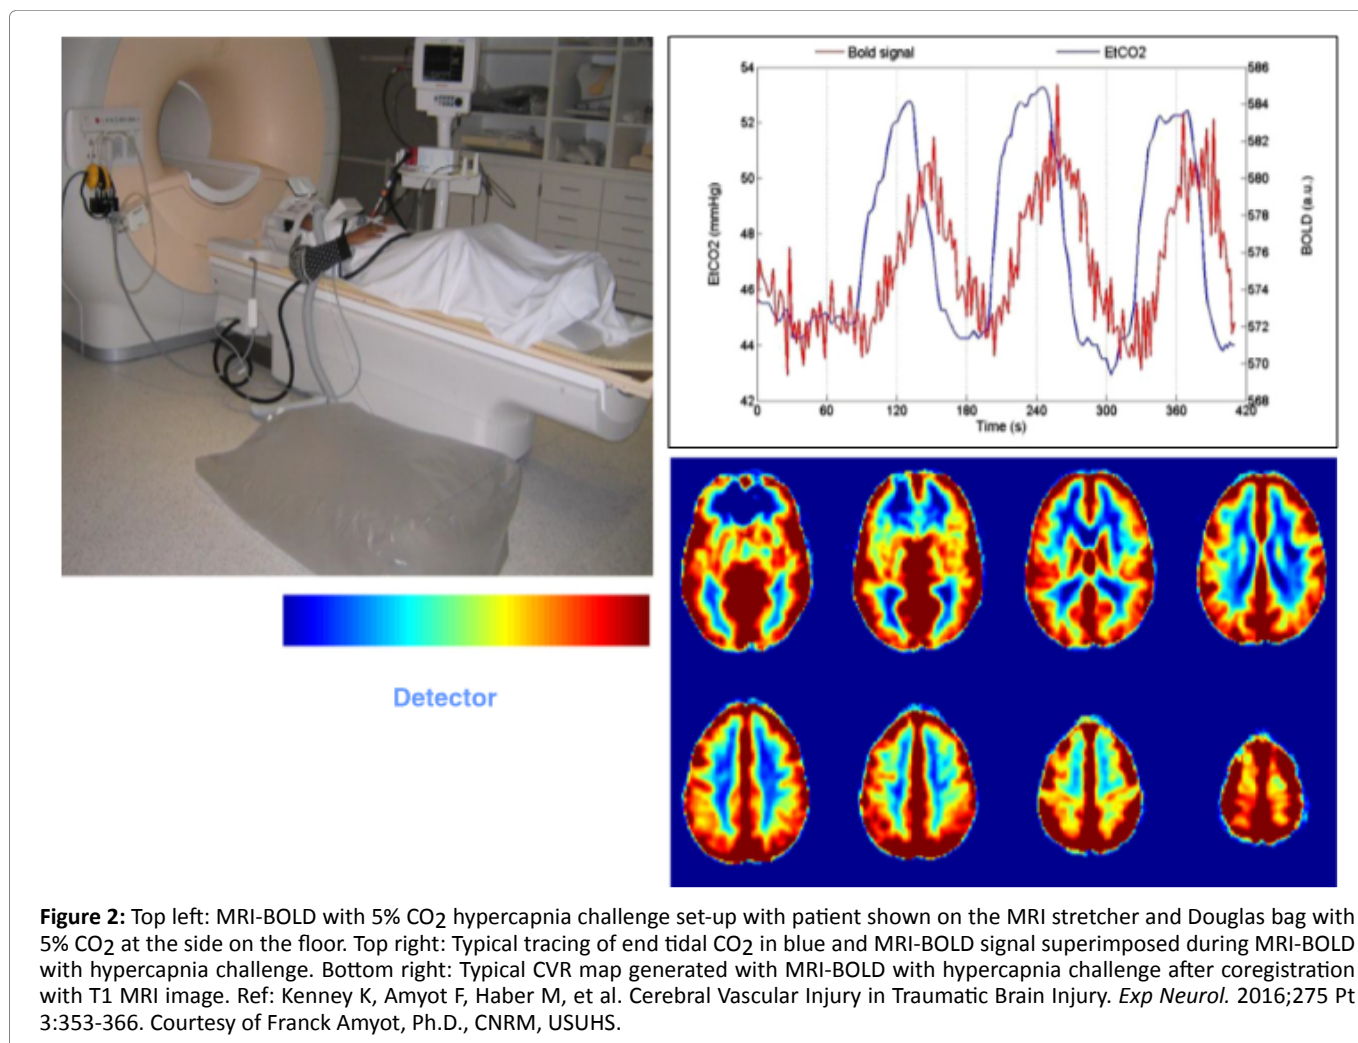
Top left: MRI-BOLD with 5% CO₂ hypercapnia challenge set-up with patient shown on the MRI stretcher and Douglas bag with 5% CO₂ at the side on the floor. Top right: Typical tracing of end tidal CO₂ in blue and MRI-BOLD signal superimposed during MRI-BOLD with hypercapnia challenge. Bottom right: Typical CVR map generated with MRI-BOLD with hypercapnia challenge after coregistration with T1 MRI image. Ref: Kenney K, Amyot F, Haber M, et al. Cerebral Vascular Injury in Traumatic Brain Injury. *Exp Neurol*. 2016;275 Pt 3:353-366. Courtesy of Franck Amyot, Ph.D., CNRM, USUHS.
